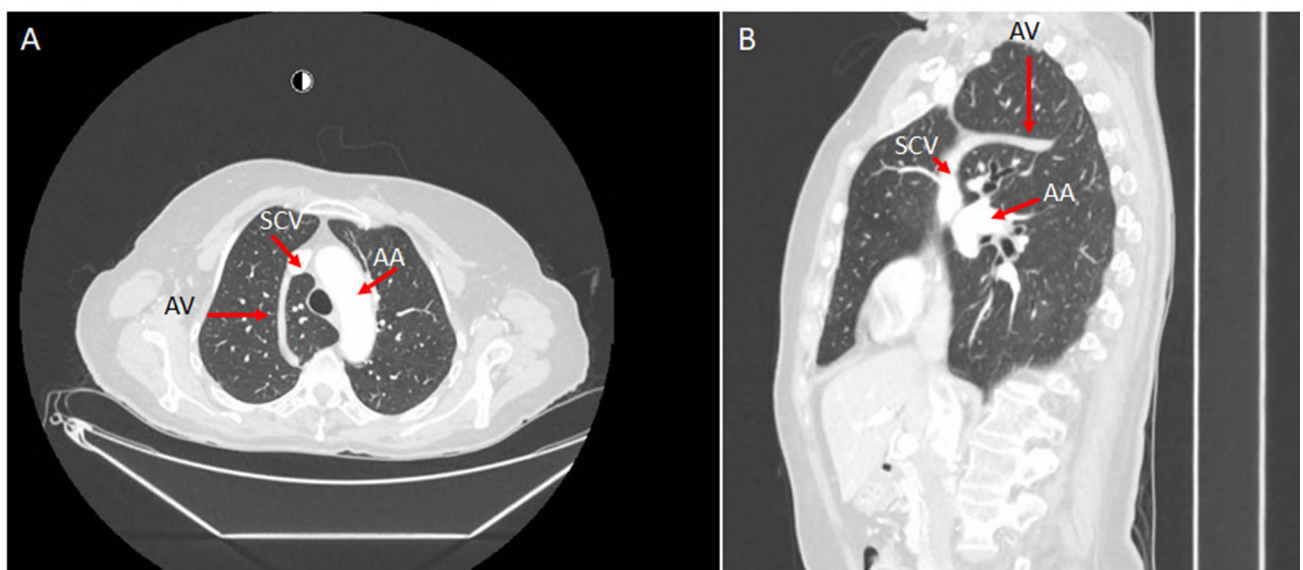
Computed tomography scan image showing an accessory azygos lung lobule in A) axial view and B) sagittal view. AV (azygos vein); AA (aortic arch); SCV (superior cava vein).
